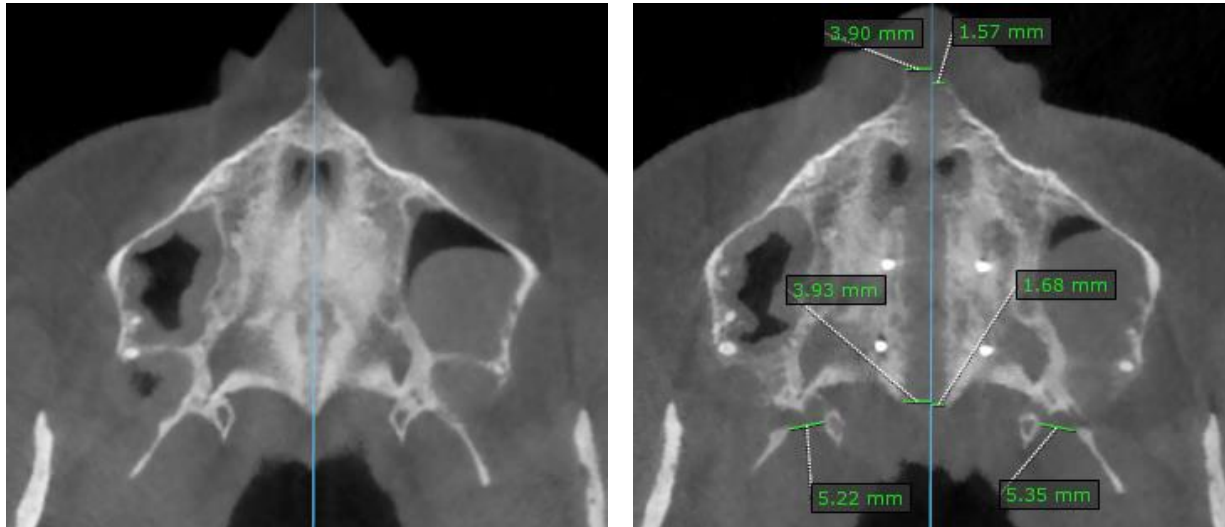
Transverse measurements on the axial palatal section (APS) in MSE patient. A: pre-expansion. B: post-expansion. Blue line: maxillary sagittal plane (MSP). MSP passes through ANS and PNS in the pre-expansion CBCT and becomes a reference line for measuring the lateral movements of skeletal landmarks in the post-expansion CBCT.
